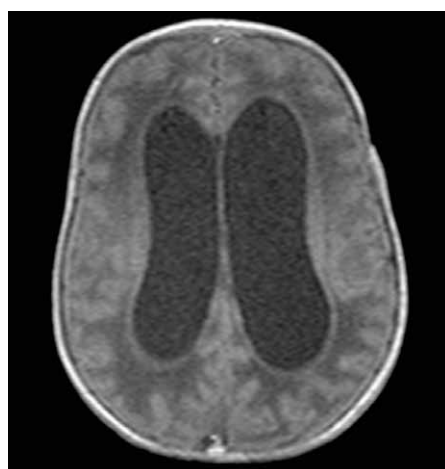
Cerebral computed tomography
